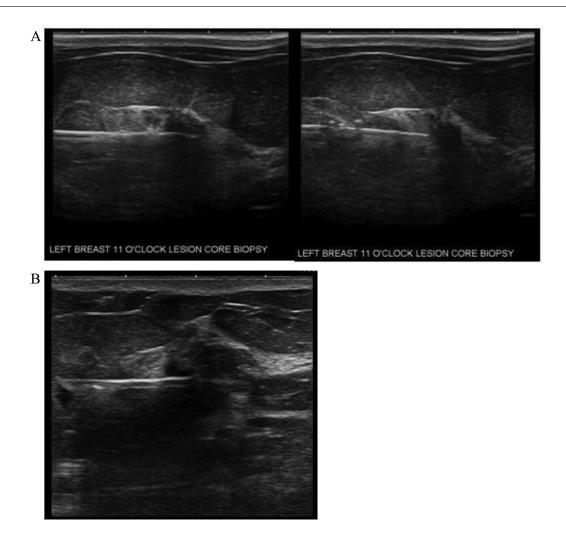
(A) Ultrasound-guided (USG) core biopsy left side. (B) USG-guided core biopsy right side.
